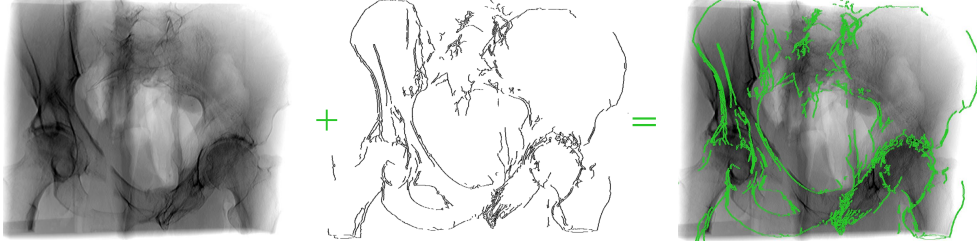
Interventional X-ray images are augmented with the contours of the bone extracted from the mirrored CT volume. The green contours serve as road-map, demonstrating desired configurations for bone fragments in the perspective of each X-ray image such that bilateral symmetry is restored.
